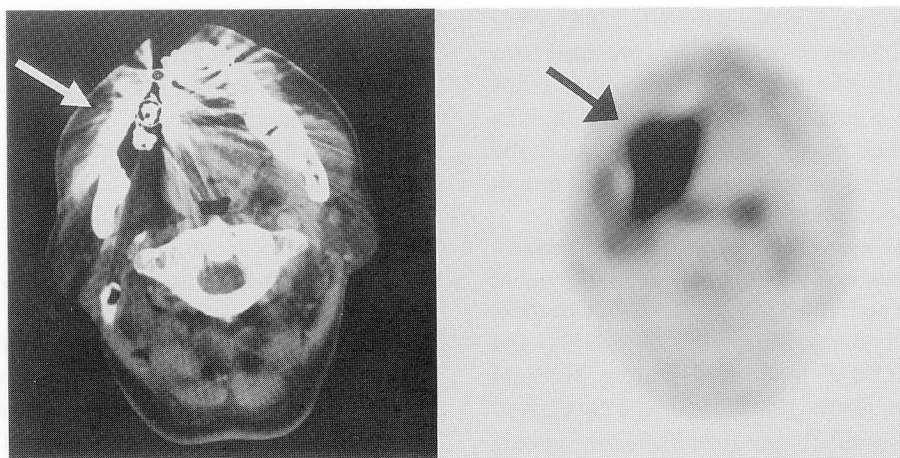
Case 23. (A) Axial CT demonstrates artifacts from dental materials near the lesion hampered the detection of primary tumor (arrow). (B) FDG-PET detected high accumulation (SUV = 7.57, T/B = 8.60) in the right mandible (arrow).
